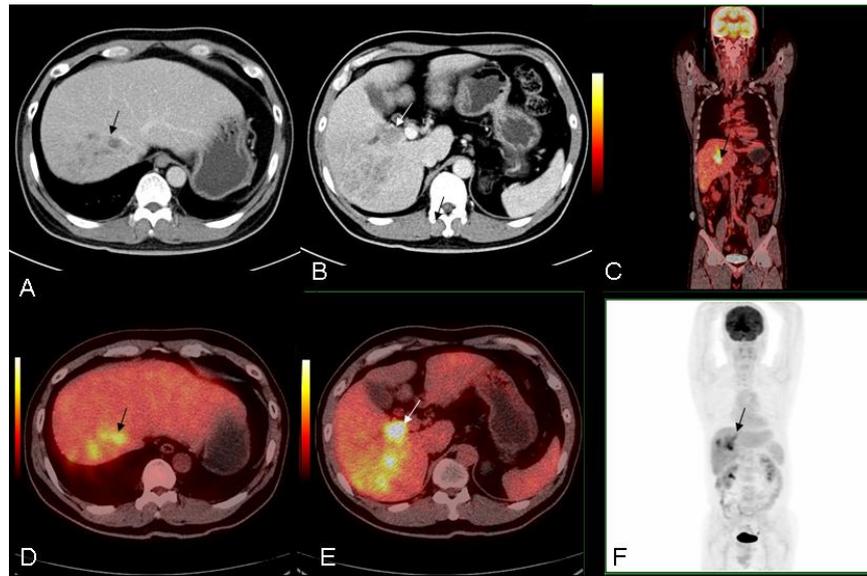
Complicated with IVC blood thrombus in the same case in Fig 2. Contrast CT scan displays right lobe mass and the IVC thrombus in the same patient. A filling defect was detected in the distant IVC (arrows in A, B and C). PET/CT fused images reveal no highly metabolic thrombus in the distant IVC, which is confirmed by imaging follow up (arrows in D, E and F).
